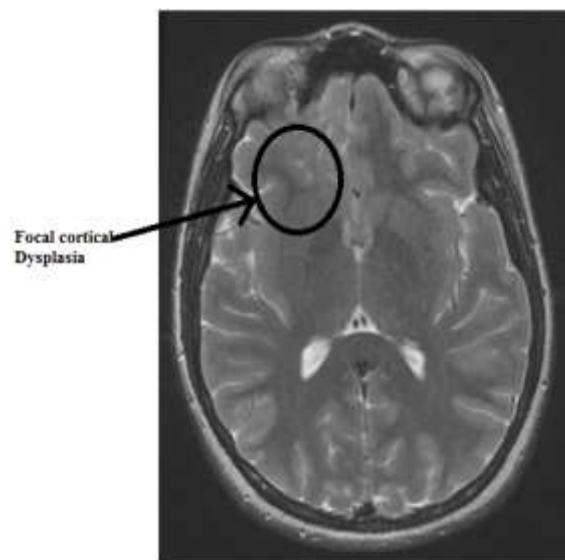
Axial T2-weighted image showing patchy irregular T2 prolongation in the inferior right frontal cortex with associated abnormal Gyral pattern and white matter, consistent with focal cortical dysplasia
